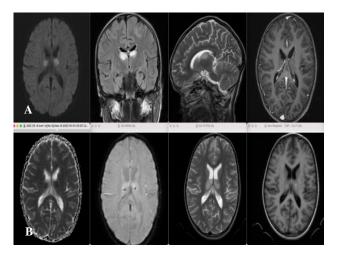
(A & B): Bilaterally symmetrical lesions of cytotoxic edema, restricted diffusion on DWI, hyperintense on T2W, FLAIR, intermediate on T1W images, in superior thalami with punctate foci of blooming on SW images represent hemorrhagic foci.
